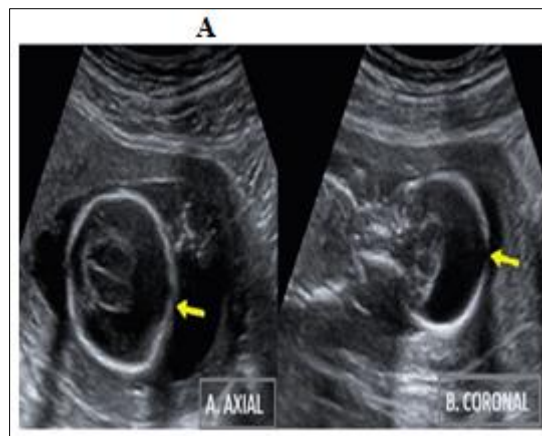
A: Axial and coronal ultrasound images showing findings suggestive of lobar holoprosencephaly
